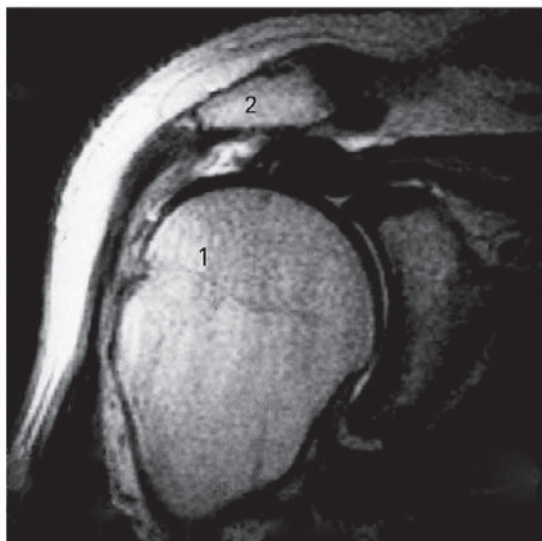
Magnetic resonance imaging (MRI) examination showing a complete tear of the rotator cuff seen from anterior. 1: Humerus (upper arm); 2: acromion (shoulder blade).
